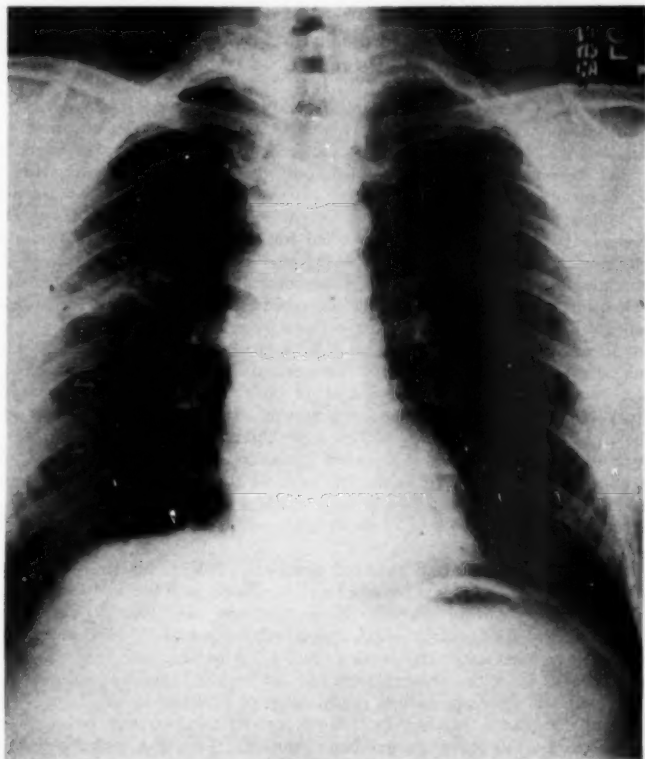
Case 3. Chest roentgenogram after six days of ACTH, demonstrating clearing of infiltration.
